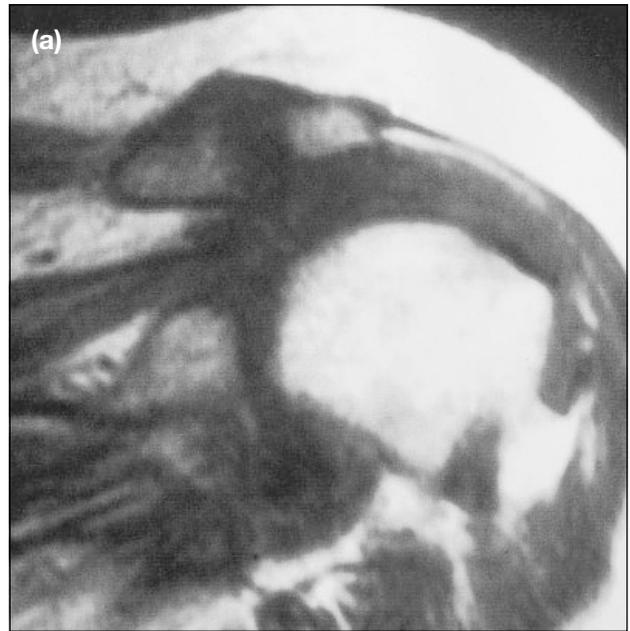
Patient with clinically active rheumatoid arthritis for approximately 2 years: oblique coronal T1-weighted images [TR 600 ms/TE 14 ms] (a) without and (b) with gadolinium. The acromiohumeral space is well preserved. The rotator cuff appears grossly intact. Following infusion of gadolinium (b), a large degree of enhancement is noted in the subacromial subdeltoid bursa. The cuff is markedly thinned (curved arrow) where synovium has invaded and destroyed tendon.
